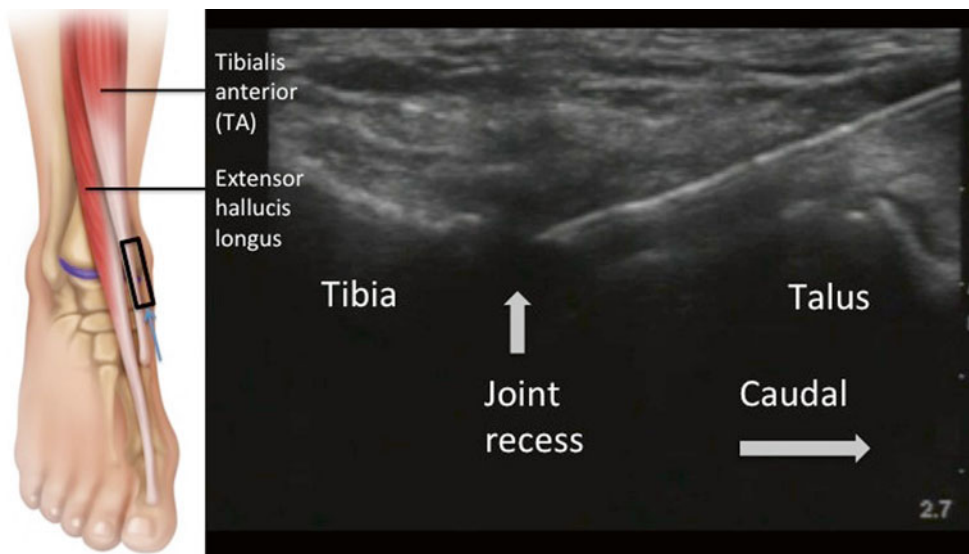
Sonogram shows in-plane needle insertion for tibiotalar joint. The insert shows the anatomy and the ultrasound probe position (Reproduced with permission from Philip Peng Educational Series)
